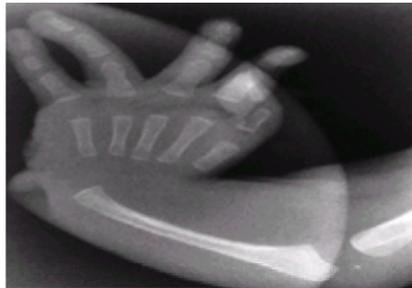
Anteroposterior radiograph of the left hand of a 1-month-old infant with bilateral radial hemimelia and essentially normal thumbs. Patient was started on a program of progressive casting and splinting, with anticipation of centralization at 6 months of age. At age 2 months, laboratory studies, obtained for evaluation of gastroenteritis, revealed thrombocytopenia with a platelet count of $17,000/\text{mm}^3$. Low platelet count continued, and centralization of the wrist was delayed.
